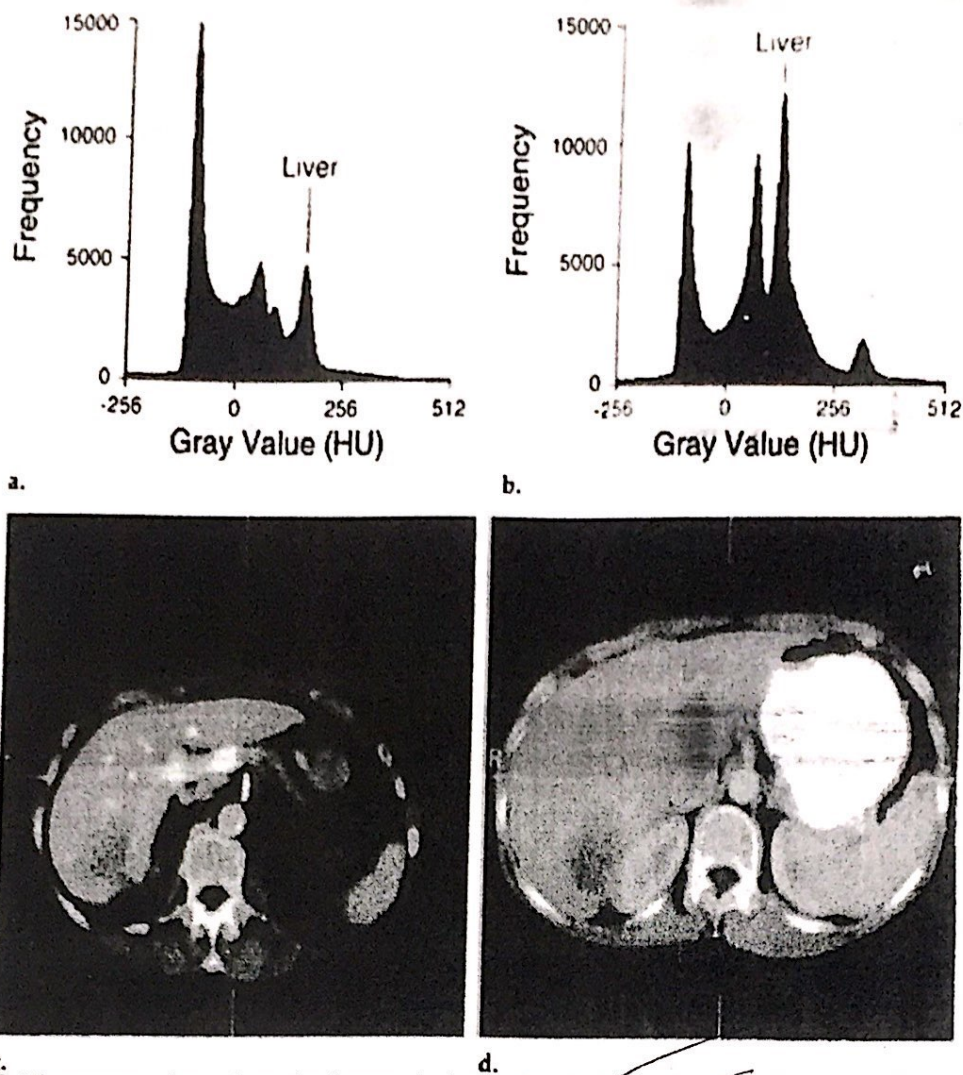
Histograms and sample section images obtained at CTAP of the abdomen and contrast-enhanced CT data sets. (a) Histogram shows a 3D CTAP data set. (b) Histogram shows a 3D contrast-enhanced CT data set. (c) Image from the data set acquired at CTAP. (d) Image from the contrast-enhanced CT data set. Note that the air portion of the histogram is not shown and the gray-level units are given in Hounsfield units (HU).
